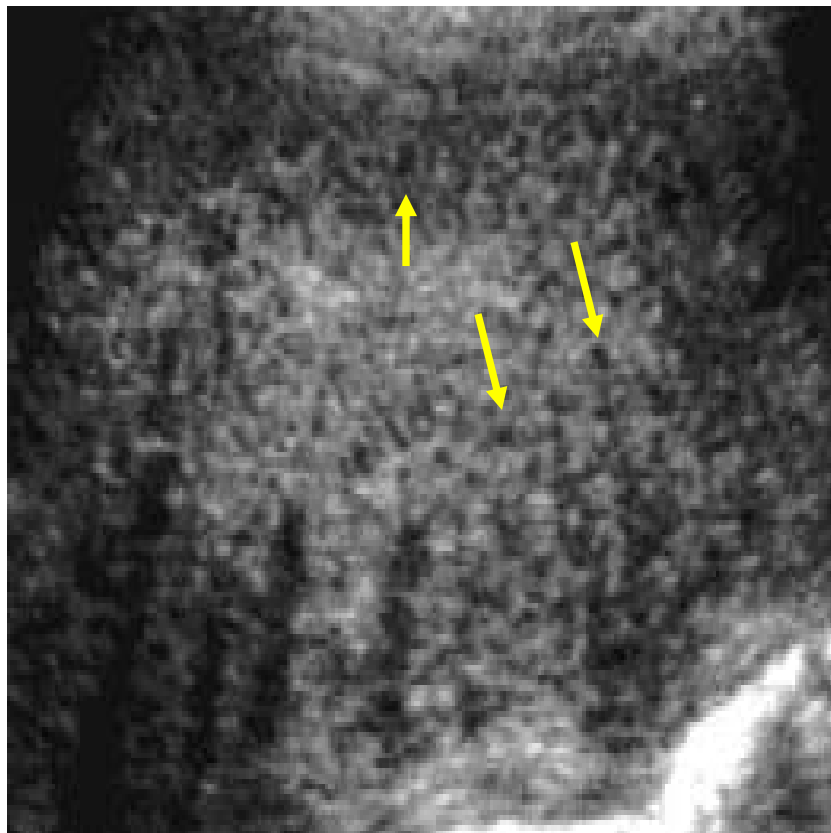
An enlargement of a transverse sonogram showing heterogeneity of the myometrium in diffuse adenomyosis. Multiple myometrial anechoic lacunae are seen (arrows).
